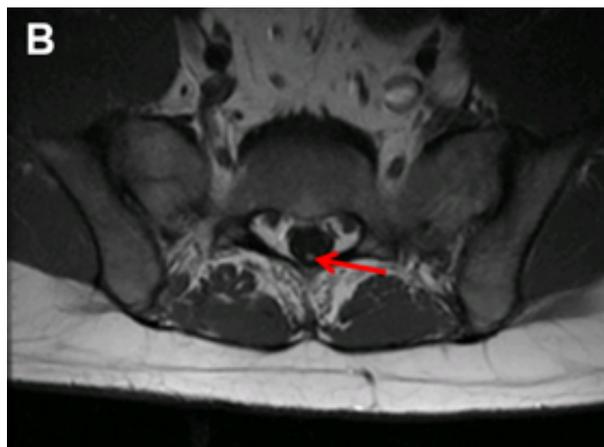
Sagittal inversion recovery (A) and axial T1-weighted (B) magnetic resonance images of the lumbar spine. The conus medullaris of the spinal cord terminates at the L2-3 level (A, white arrow). T1-weighted axial image demonstrates fat intensity signal involving the filum, consistent with a fatty filum terminale (B, red arrow).
